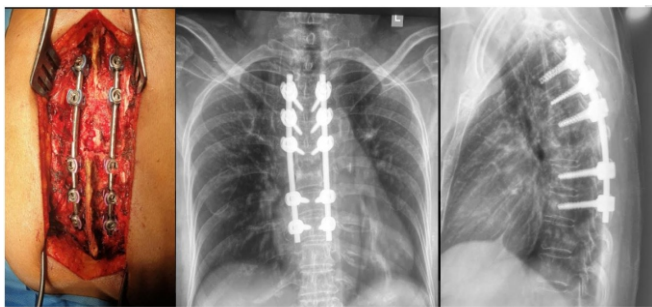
a) intra-operative, b) and c) show immediate post-op X-ray dorsal spine AP and Lateral view.
